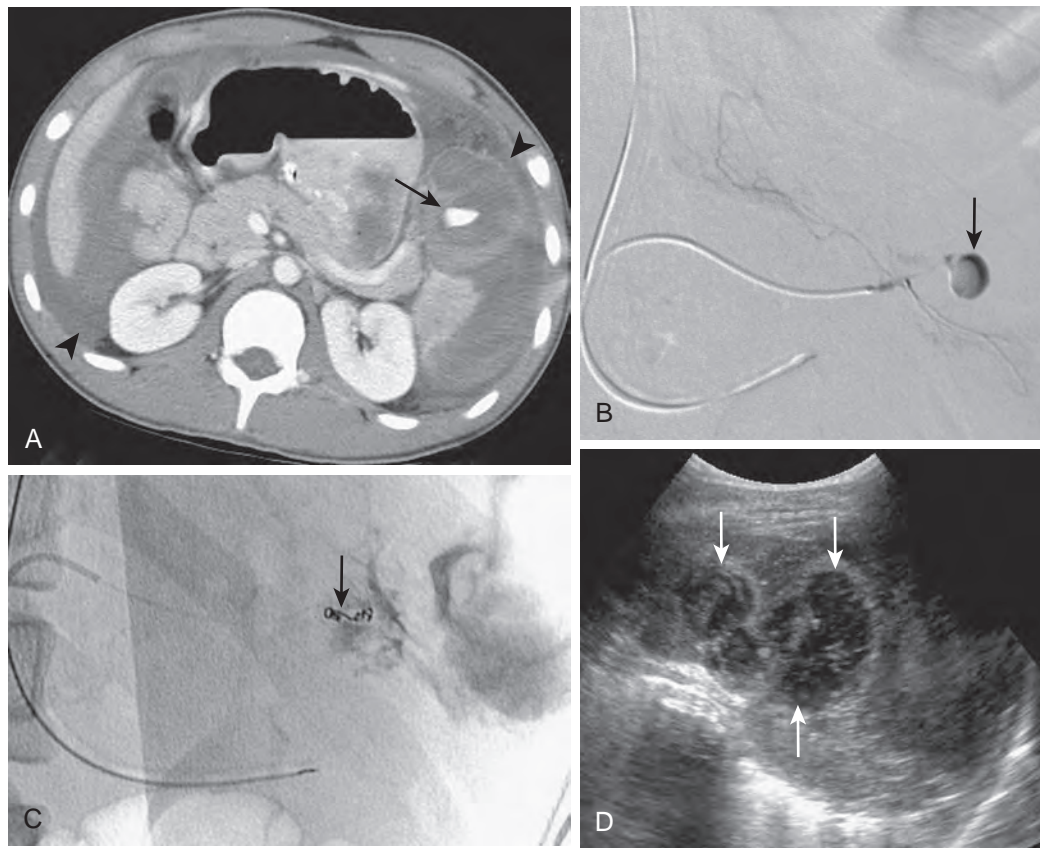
Splenic trauma. A. Contrast-enhanced CT of 14-year-old boy with a splenic injury after a motor vehicle collision. One month later, the boy had a syncopal episode and was hypotensive. The healing fractured spleen had spontaneously ruptured. Intraperitoneal blood surrounds the liver and the fractured spleen (arrowheads). There is a mixed-attenuation hematoma with a focal concentrated collection of extravasated intravenous contrast material (arrow), indicating active bleeding in the anterior aspect of the spleen. B. Selective arteriogram of a splenic end artery demonstrates focal extravasation (arrow). C. Coil (arrow) embolization was performed to stop hemorrhage. D. Healing spleen has a heterogeneous echotexture. Relatively hypoechoic areas (arrows) are likely to represent an evolving hematoma and necrotic splenic tissue.
